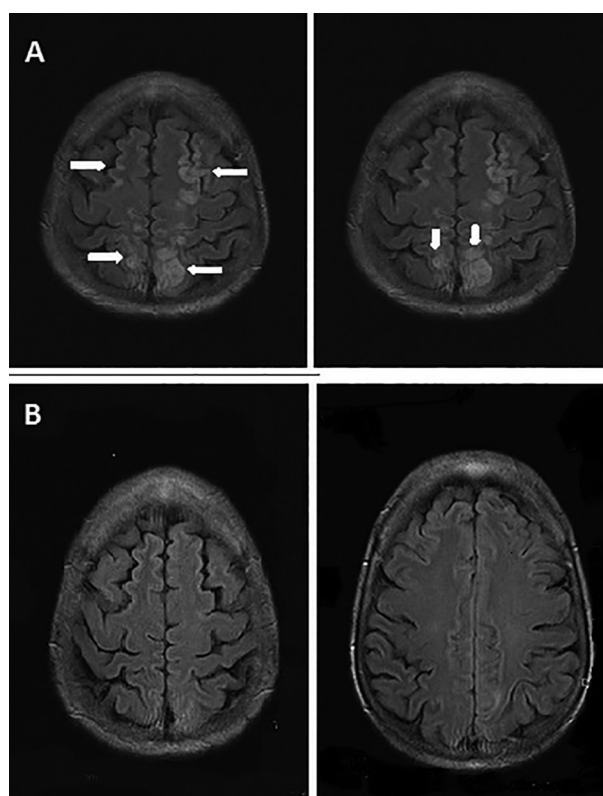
A : FLAIR hyperintense cortico-subcortical signals in the occipital, parietal and anterior regions. B : Complete resolution.
